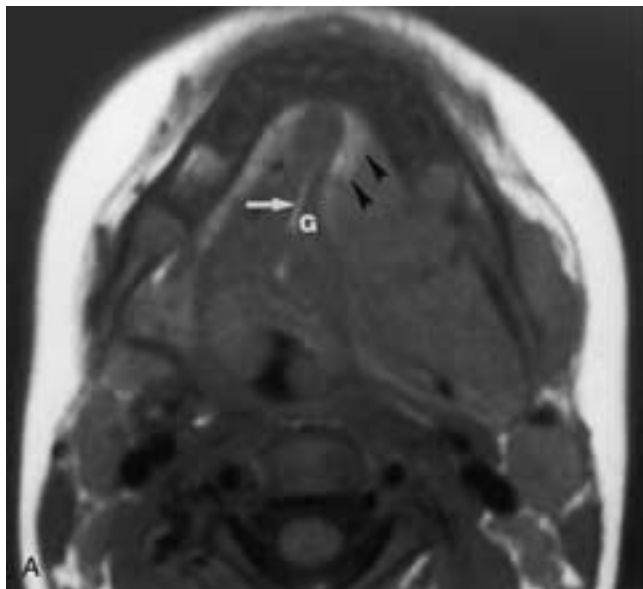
Aggressive fibromatosis. Axial T1-weighted (A) and T2-weighted (B) MR images demonstrate a left submandibular space lesion that is minimally hyperintense to muscle on A becoming progressively more hyperintense on B. Although the lesion can be separated anteriorly from the fat-filled sublingual space on the T1-weighted image (*arrowheads* in A), separation on the T2-weighted image is not possible. Note the compression of the left genioglossus muscle (*G*) and displacement of the midline lingual septum to the right (*arrow*). (Courtesy of Dr. Jan Casselman.)
